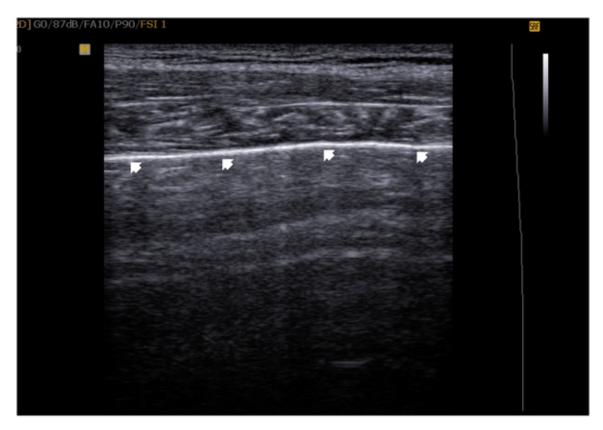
Ultrasonographic image shows smooth echogenic normal lung surface (arrow).
